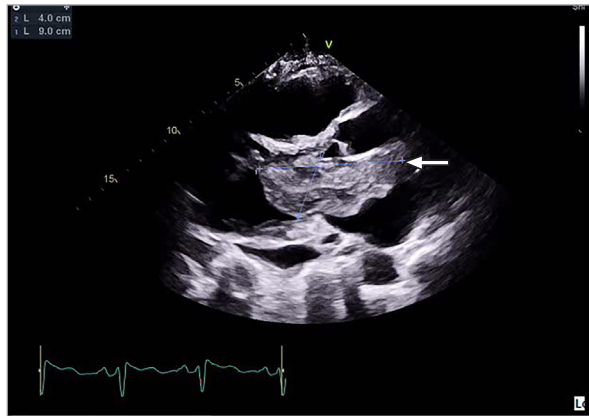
A 2-dimensional transthoracic echocardiogram provides a parasternal long-axis view of the patient's myxoma. The arrow shows the myxoma protruding from the mitral valve. The myxoma measured 4.0 × 9.0 cm.
